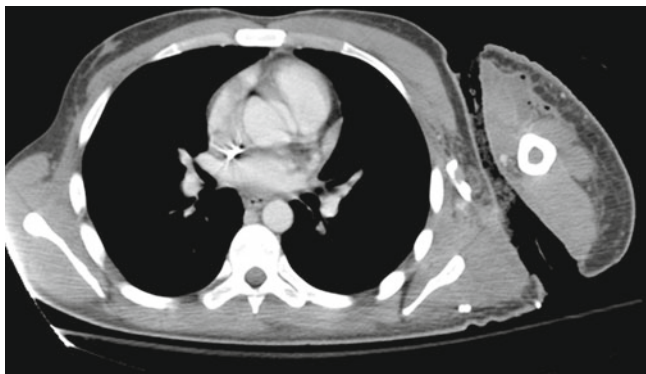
NSTI computed tomography appearance. Author's collection
